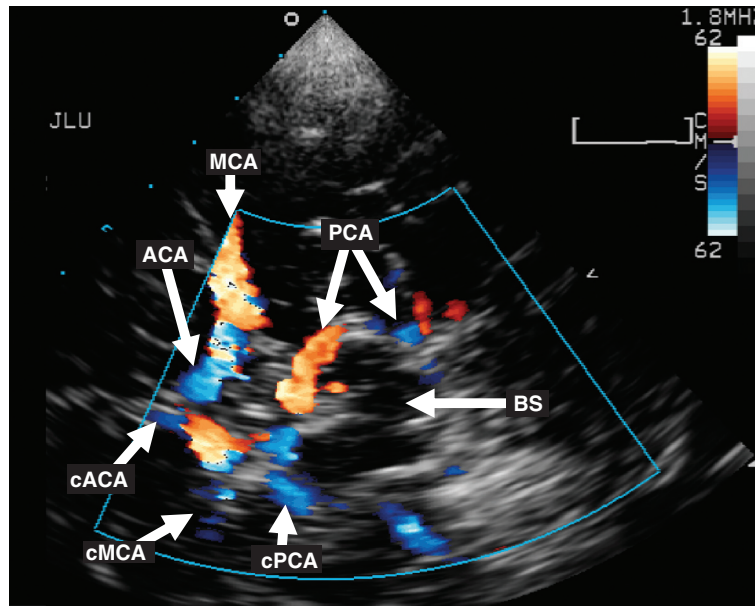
Color coded duplex sonography: circle of Willis. BS = brainstem; MCA = middle cerebral artery; cMCA = contralateral MCA; ACA = anterior cerebral artery; cACA = contralateral ACA; PCA = posterior cerebral artery; cPCA = contralateral PCA.
